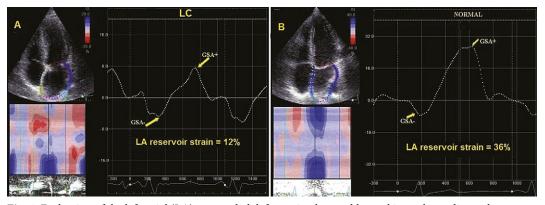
Evaluation of the left atrial (LA) myocardial deformation by speckle-tracking-echocardiography A. Decreased LA booster (GSA-), conduit (GSA+), and reservoir strain (the sum of GSA- and GSA+ in absolute values), in a female patient with liver cirrhosis, 52 years old. LA reservoir, booster, and conduit strains are assessed from apical 4-chamber view. B. Normal atrial deformation in a normal subject with similar age and gender.
